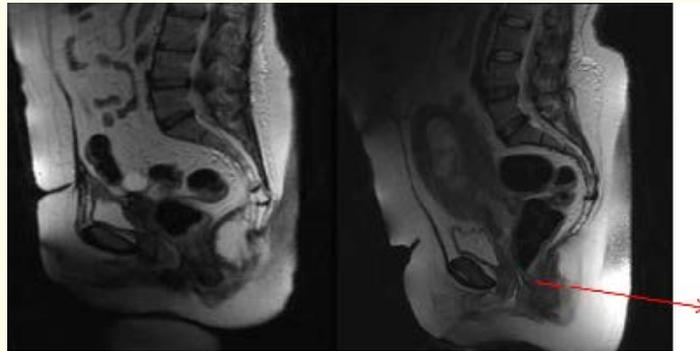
MRI images, sagittal sections; Image (A) there are torn both IUS, which causes funneling of the bladder neck leading to OAB; and torn IAS that leads to FI. In image (B), there is an intact IAS with closed and empty anal canal, but there is torn IUS in its upper end causing funneling of the bladder neck that leads to urge and urgency incontinence.
